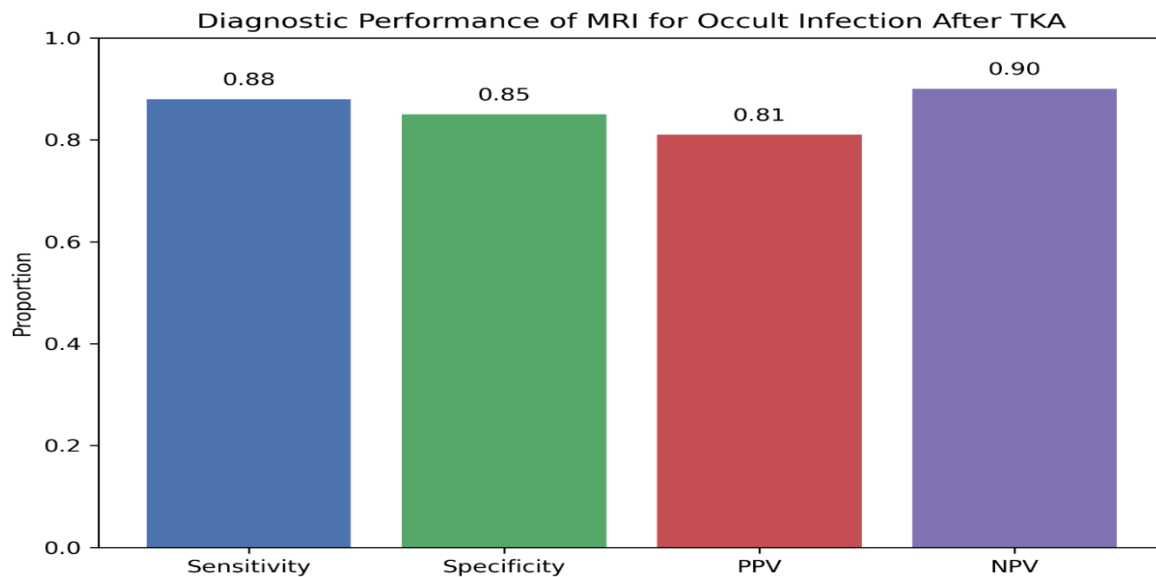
Diagnostic performance of MRI for detecting occult periprosthetic joint infection after total knee arthroplasty
